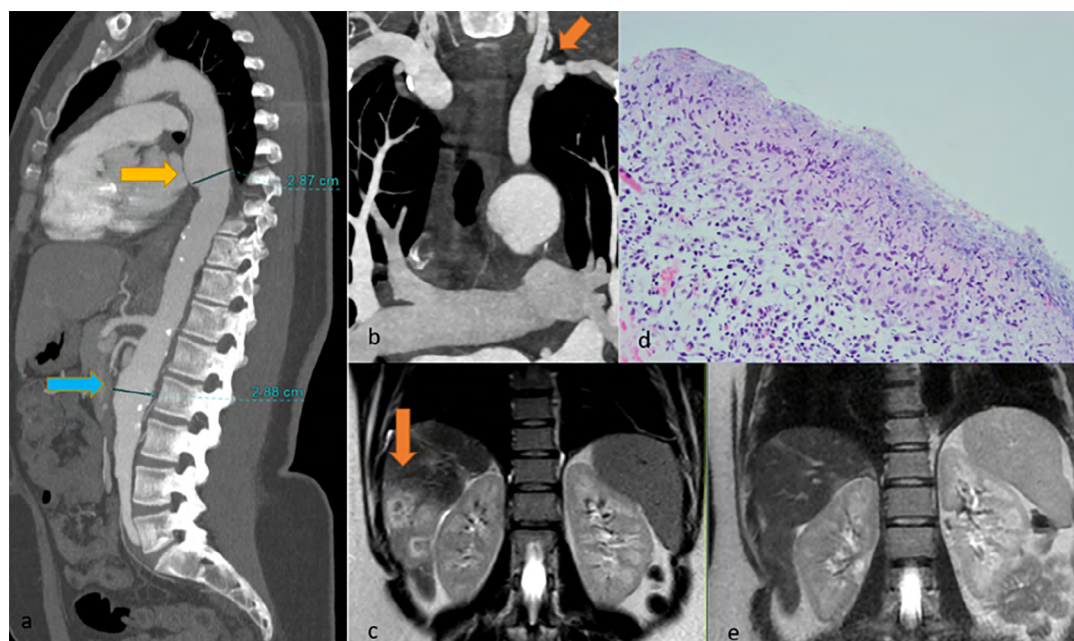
Contrast enhanced CT: aortic root aneurysm (a, yellow), fusiform aortic aneurysm of the infrarenal abdominal aorta (a, blue) and left subclavian artery stenosis (b); Contrast-enhanced (CE) abdominal CT: hepatic confluent oval focal hyperintense lesions with a hypointense center compatible with metastases; Non-necrotizing epithelioid granuloma with inflammatory signs and eosinophilia (d); Follow-up CE abdominal CT: no lesions (e).
